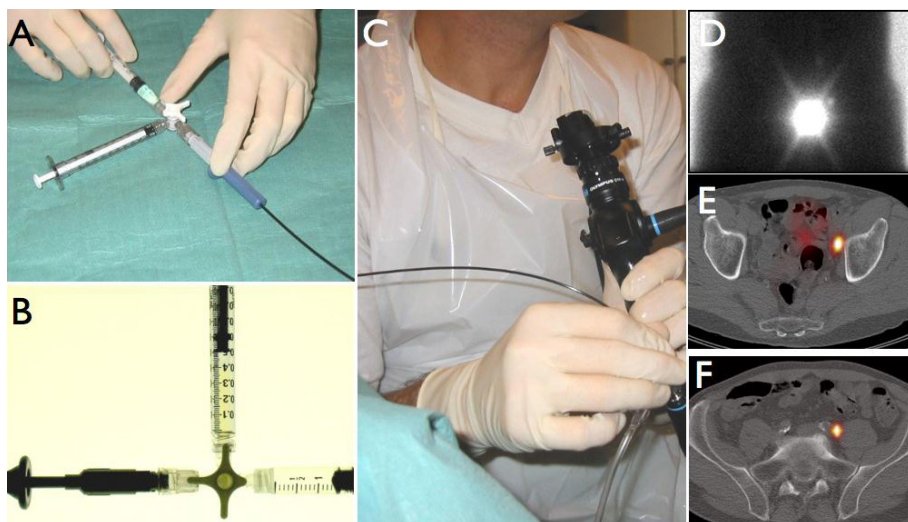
Radiocolloid injection in bladder cancer using a needle fitted over a three way stopcock with one Luer Lock system (A, B), under endoscopic guidance (C). Early anterior planar scintigraphic image (D). SPECT/CT imaging reveals left iliac lymphatic drainage with SLNs along the iliac vessels (E, F).
